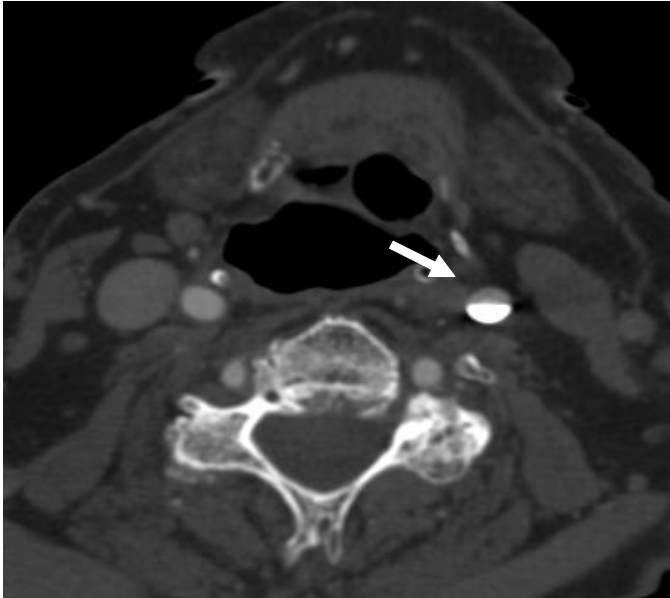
CT angiogram, Axial enhanced images through the neck, demonstrating no flow through left common carotid artery. Arrows pointing to the area where LCCA should be seen.
